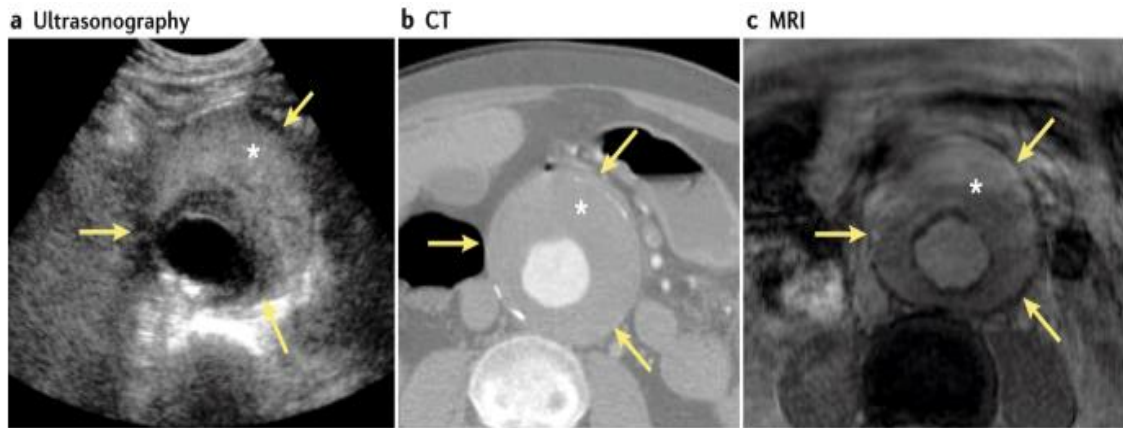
AAA as Seen with Different Imaging Modalities. These three images show AAAs with parietal thrombus, indicated by the asterisk, as seen with different imaging modalities. Image A is using US, Image B is using CT, and Image C is using MRI.
